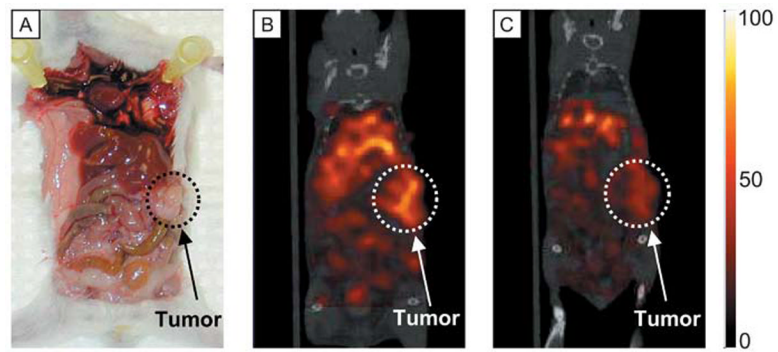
(A) Photograph of a representative orthotopic pancreatic tumor, and *in vivo* SPECT/CT images (coronal view) at 6 hours after (B) Tc-99m-TRA-8 or (C) Tc-99m-isotype control antibody injection intravenously. The same color scale was applied for both the SPECT images.
